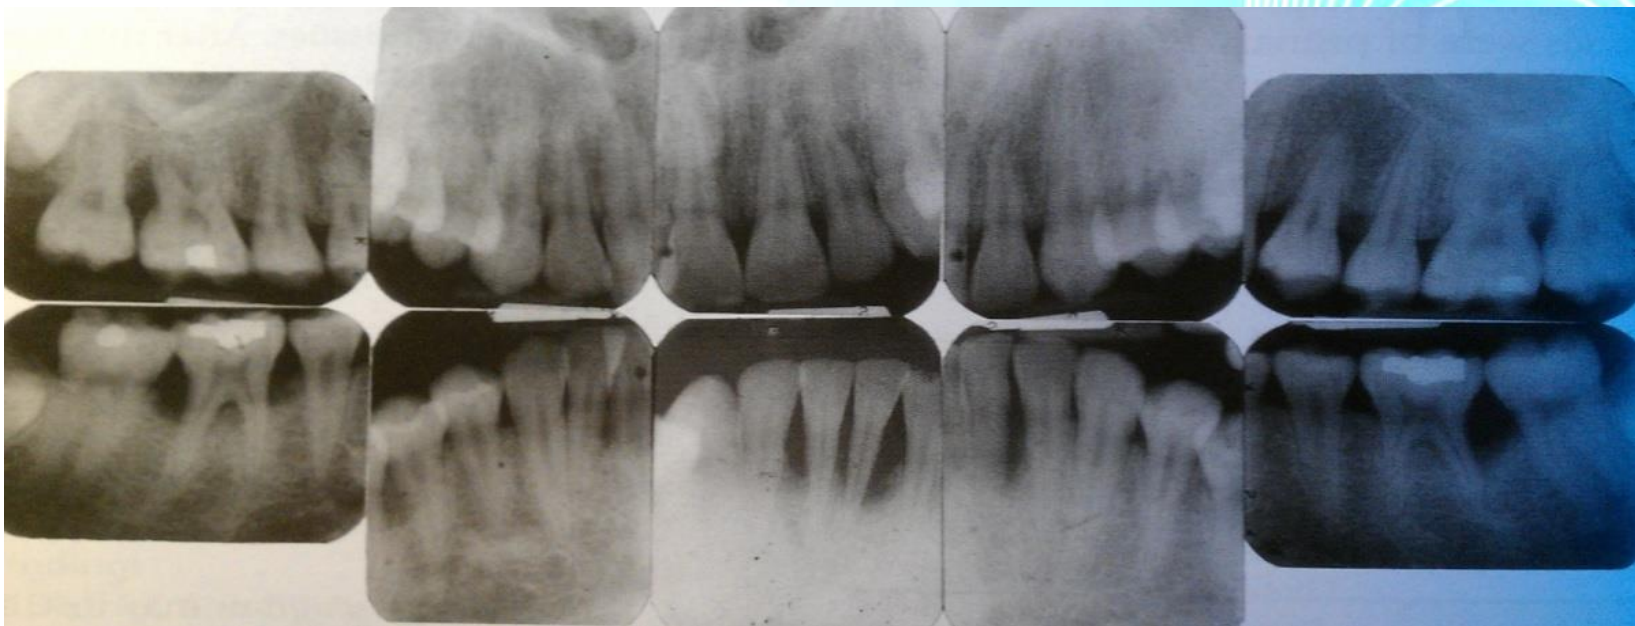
Rays showing localized vertical angular bone loss
